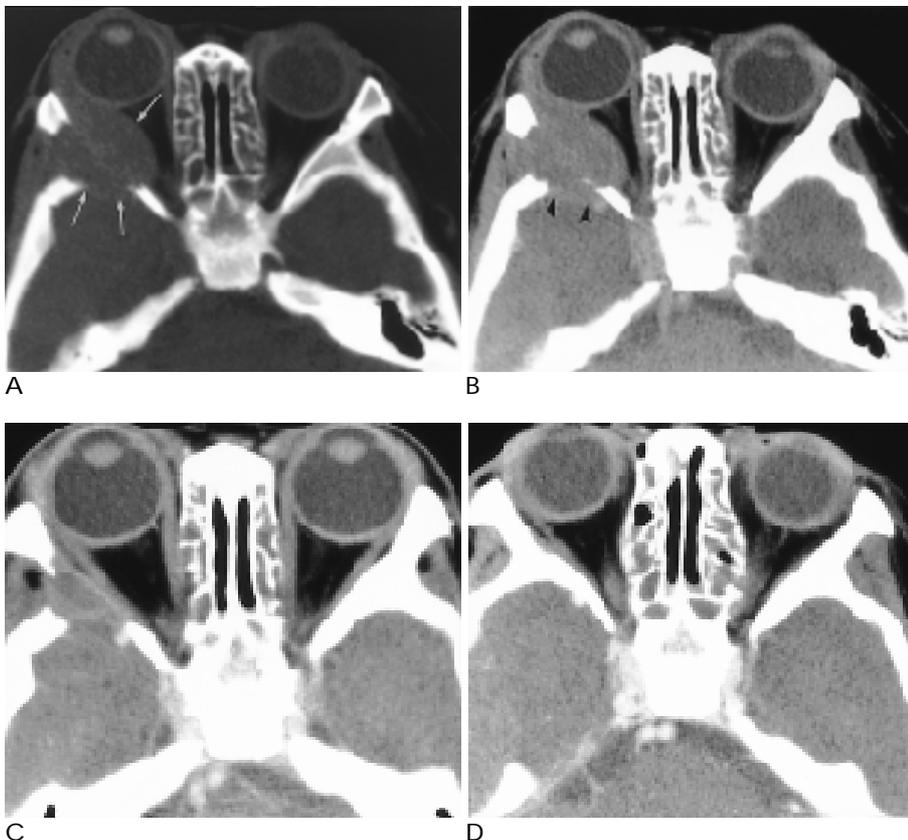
Case 1. 1.5-year-old girl presented with right exophthalmos. Unenhanced CT (A) and enhanced CT (B) show a large soft tissue mass (arrows) with bone destruction involving lateral wall of right orbit. Minimal, peripheral enhancement is seen in B. There is intracranial extension (arrowheads) without intraconal extension. After 3 months, follow-up enhanced CT (C) shows marked improvement of soft tissue mass. Follow-up CT (D) after one year shows bone remodeling and reossification without residual soft tissue mass.
